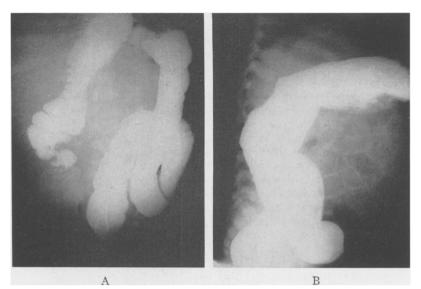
Roentgenograms, A. anteroposterior, and B. lateral, demonstrating inferior and posterior displacement of right colon.
